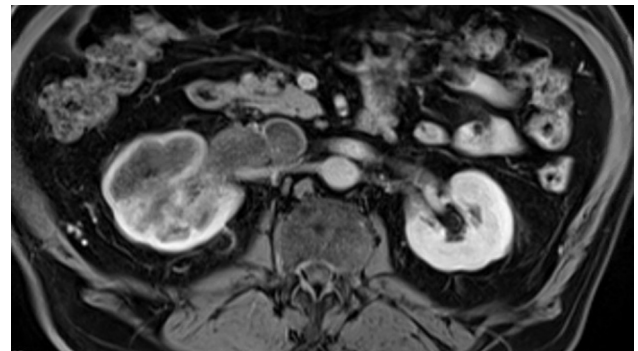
Axial magnetic resonance image of abdomen displaying renal vein and inferior vena cava (IVC) extension.
